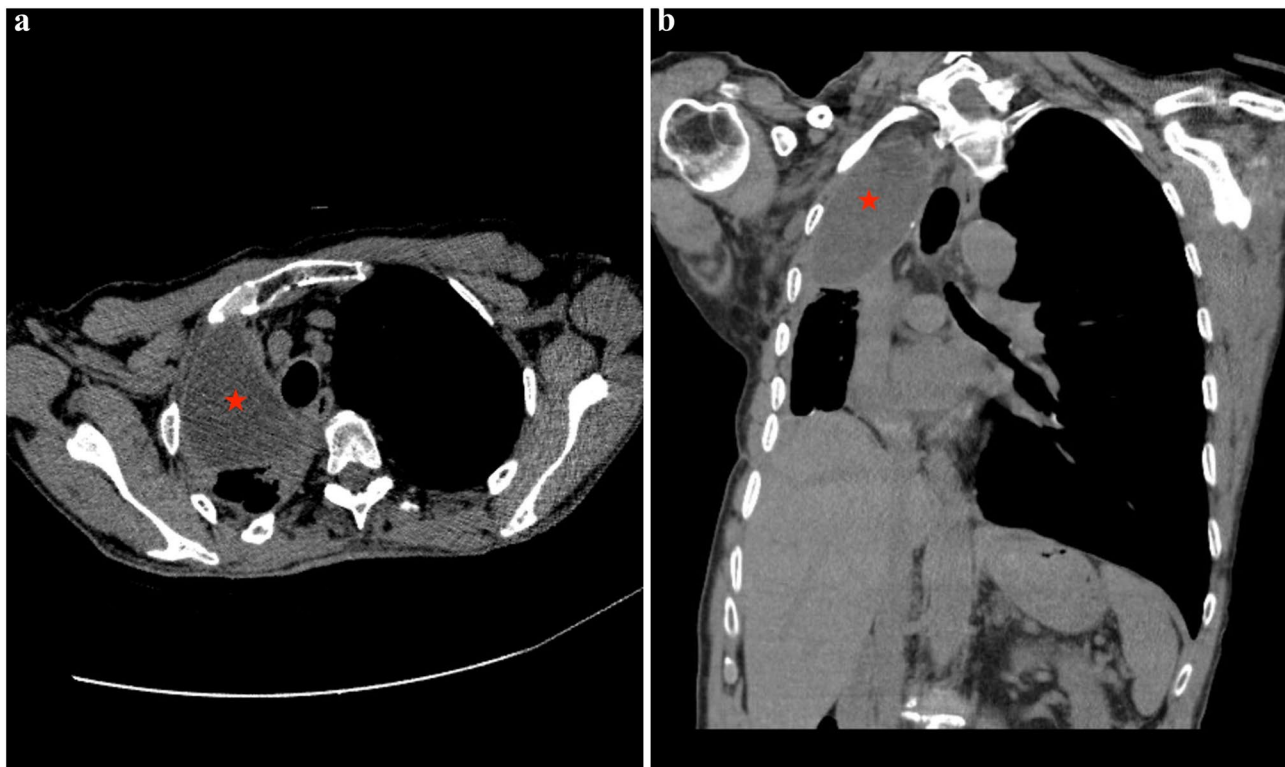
Axial (a) and coronal (b) CT sections show a pleural pocket located in the right upper lung zone. The area marked with an arrow indicates the pleural pocket
